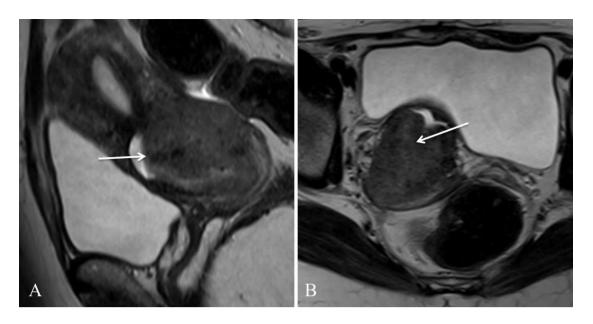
Sagittal (A) and Axial (B) T2 weighted MRI showing cervical mass (white arrow) extending to bilateral parametrium with mild endometrial collection staged as IIB.
